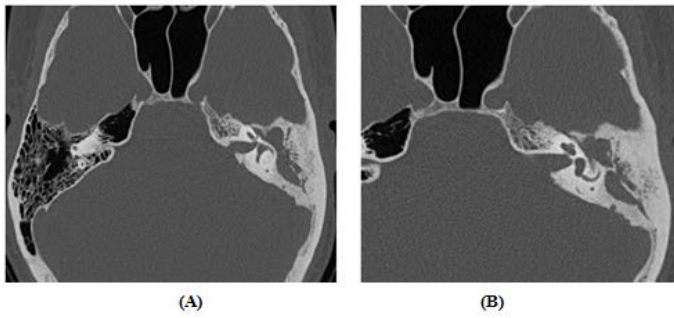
(A) and (B) axial HRCT temporal bone, show left sided cholesteatoma with ossicular chain disruption and erosion of tympanic segment of facial nerve canal, s/o left extensive cholesteatoma
